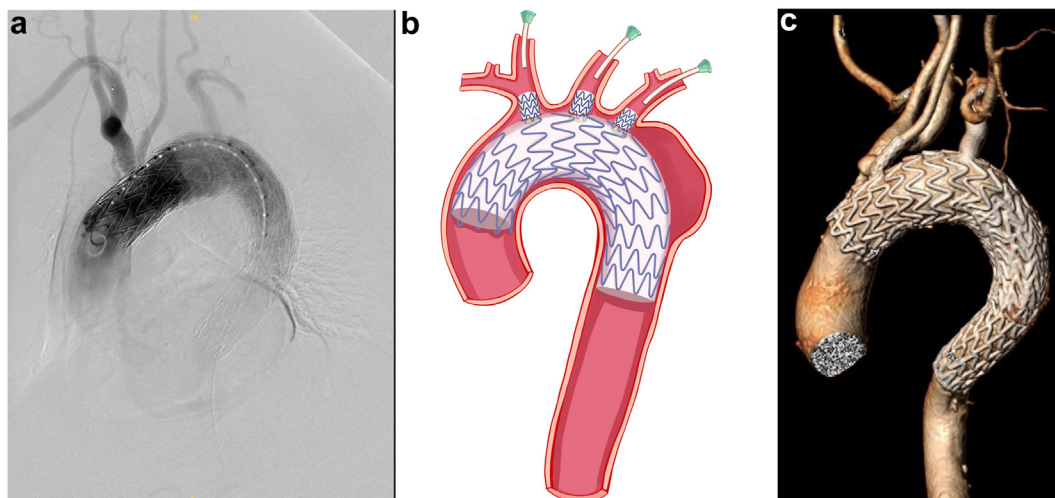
A,B, Completion angiography confirming an entirely covered lesion and satisfactory blood flow to three supra-aortic branches. C, Computed tomography angiogram showing fully occluded aneurysm and three patent branches at 3-month follow-up visit.
